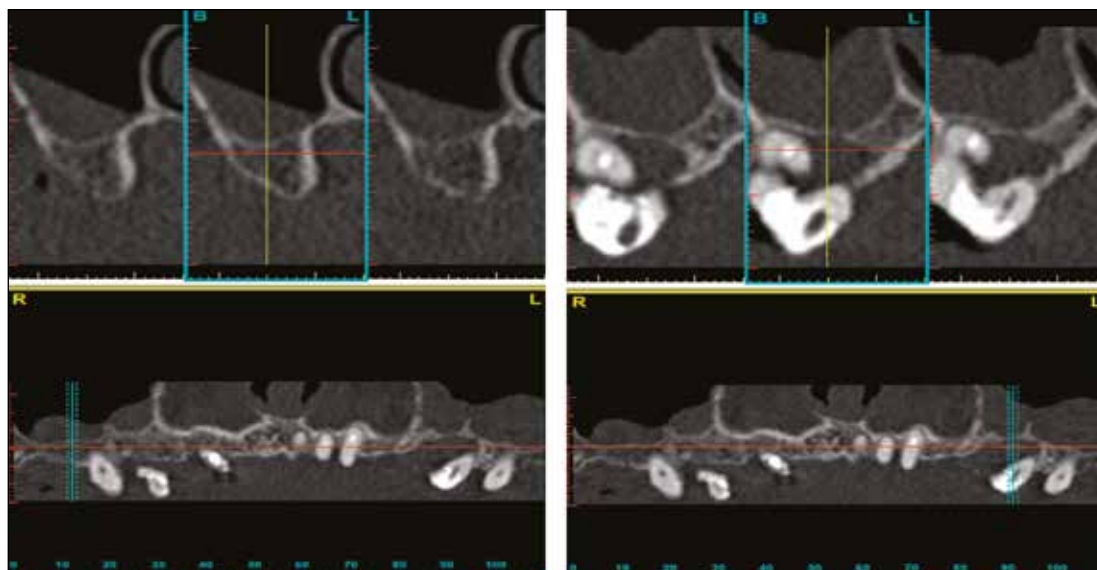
Fragment of computed tomography of the upper jaw of the 61-year-old female patient A., case record No.63. Diagnosis: edentulism of the upper jaw, Kennedy Class III-2, chronic periodontitis of teeth #16, 26, 27. Bilateral thickening of mucous membrane and cystic mass on the left.
